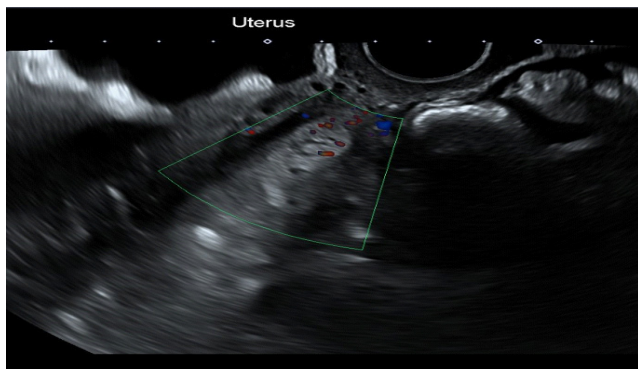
longitudinal view TV ultrasound showing a thickened and cystic endometrium.
